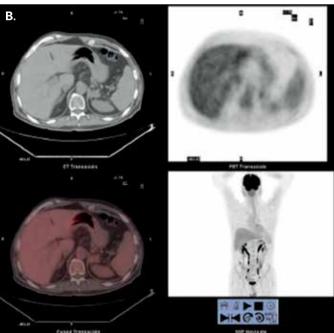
A and B positron emission tomography-computed tomography show focus of intense fluorodeoxyglucose uptake in bilateral adrenal masses. The left adrenal mass is bigger than the right. There is another focus with fluorodeoxyglucose uptake in ileocecal site
